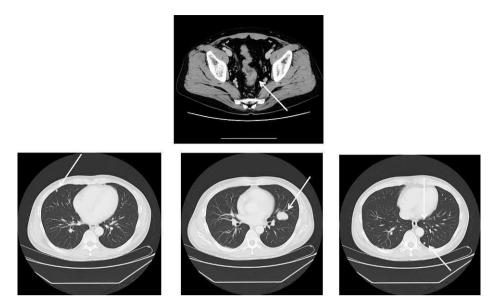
The CT image shows a thickening of the rectal wall (Rs), a 33-mm pulmonary nodular lesion in the left lung field (S4), and multiple pulmonary nodular lesions of 1 cm or less in the left and right lung fields (arrow).
